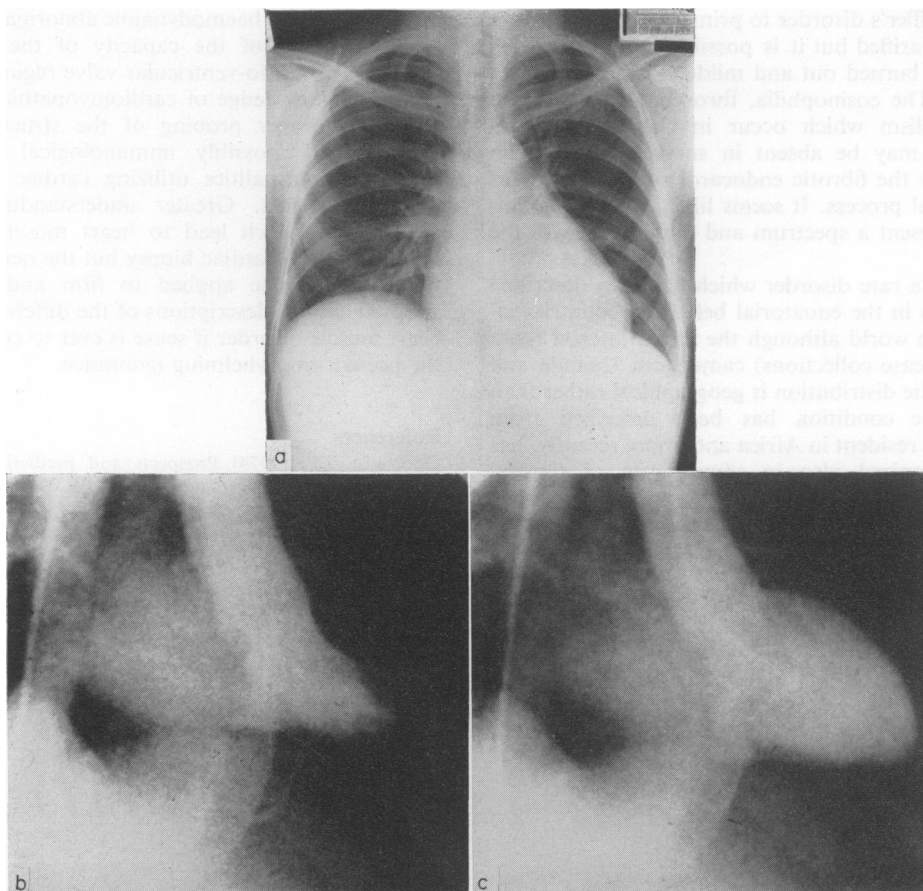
(a) Plain radiograph of the chest in ROCM; the heart is not enlarged; there is slight pulmonary venous congestion; (b) frontal view left ventricular angiogram in ROCM in systole, and (c) in diastole. The left ventricular contraction is normal. There is some mitral regurgitation. The outline of the ventricle is unduly smooth and the apex appears a little obliterated.
